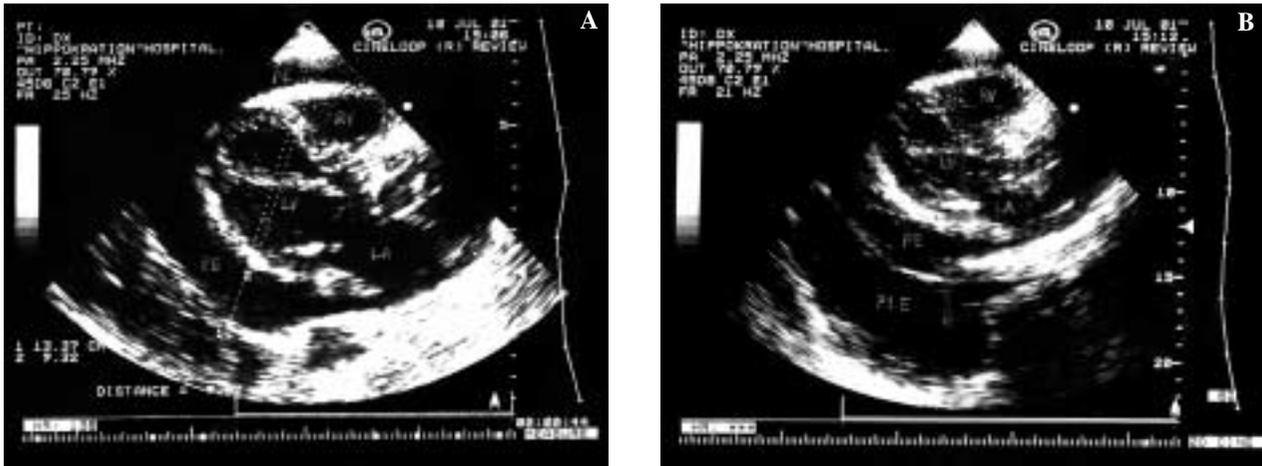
Two-dimensional echocardiogram. Long axis parasternal view. There is a large pericardial (1A, 1B) and pleural effusion (1B). The quantity of pericardial effusion was calculated at approximately 1500 ml. PE=pericardial effusion, PLE = pleural effusion, LA= left atrium, LV= left ventricle, RV= right ventricle.
